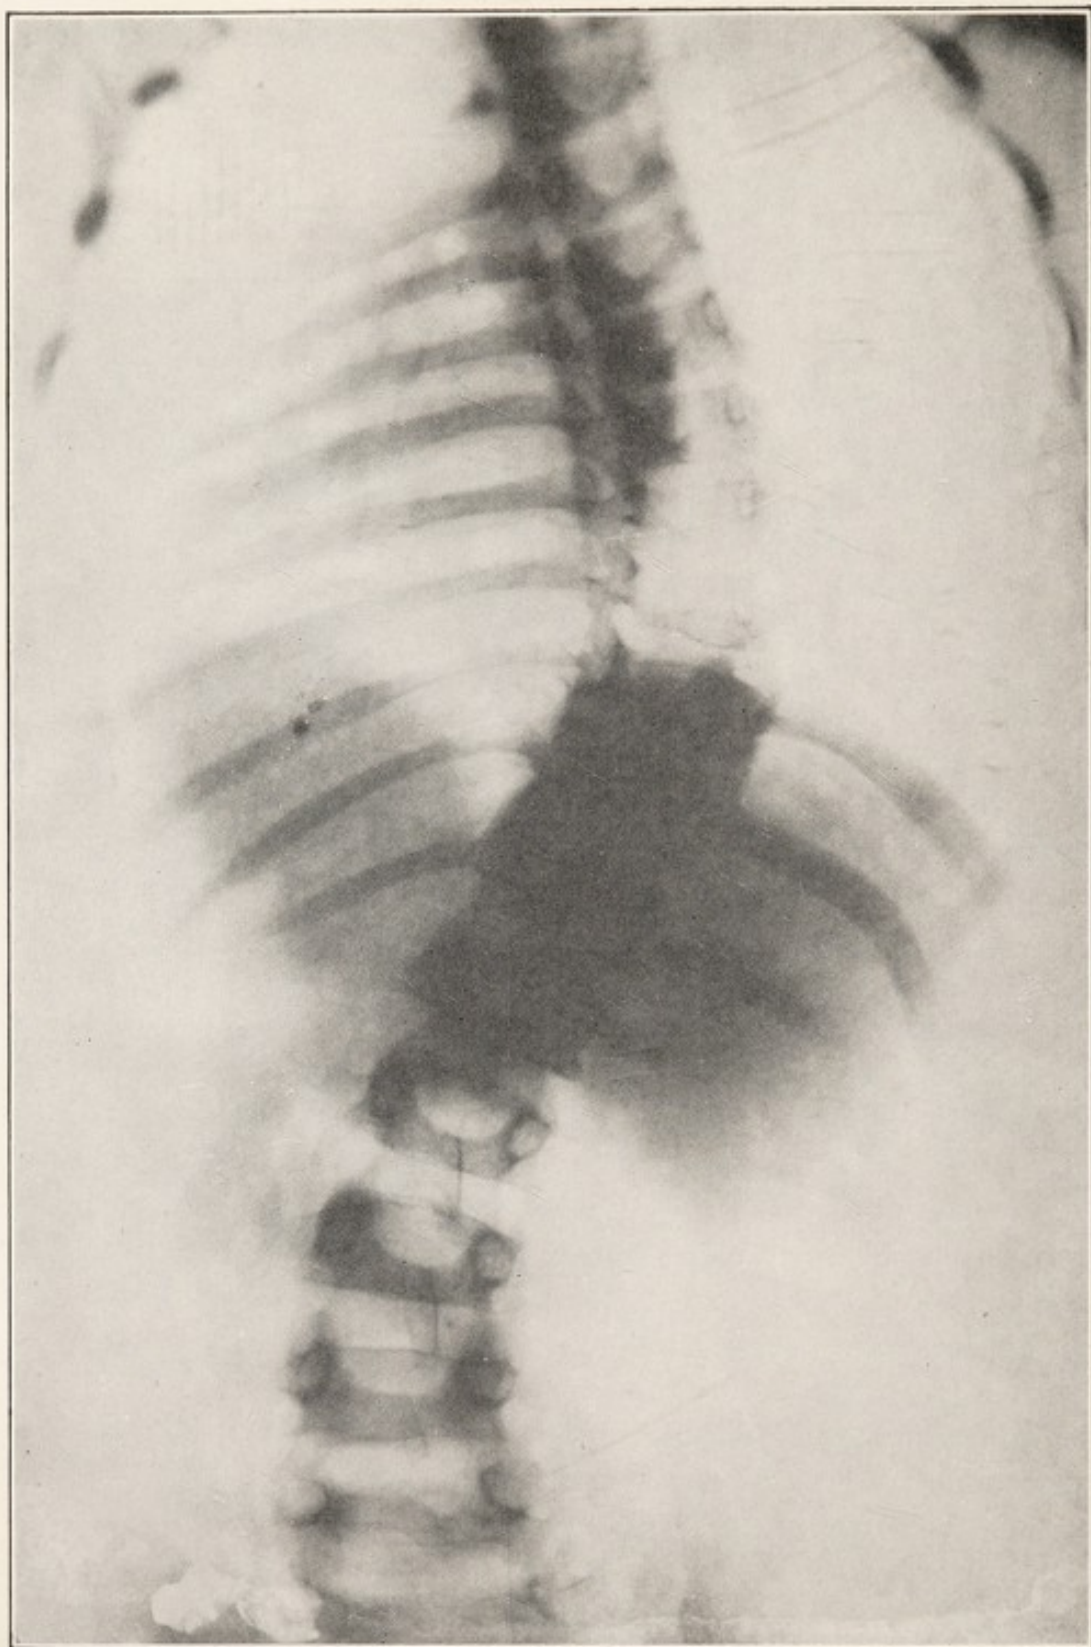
X-RAY OF SCOLIOSIS, RIGHT DORSAL, LEFT LUMBAR, SHOWING ROTATION OF BODIES OF VERTEBRÆ.
